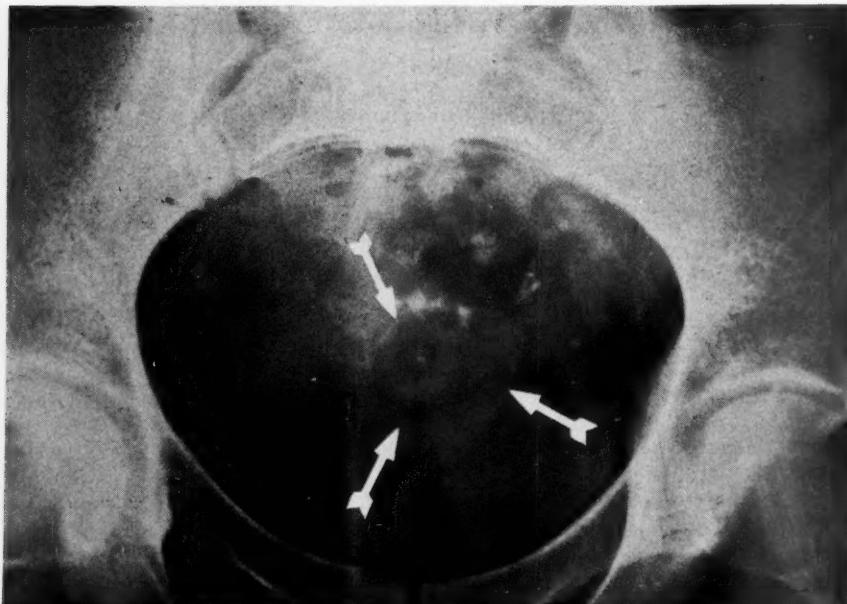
X-ray of the Pelvis. Arrows show circular area of calcification.
